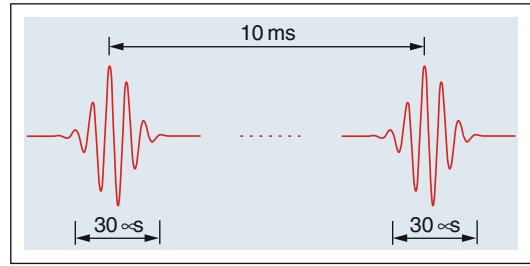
Among other signals, dolphins send out sequences of ultrasound pulses to locate and scan objects based on their echoes. The figure shows two typical pulses from a series with regular intervals. The intervals between the pulses are long enough that an echo has time to return. Repetition frequency $\approx 10^2$ Hz; ultrasound frequency $\approx 10^5$ Hz. Number and pulse forms are just examples; depending on the species, they can vary a lot. In addition, dolphins in groups use lower frequencies to whistle to each other. The pulse-echo technique is also used in medicine
